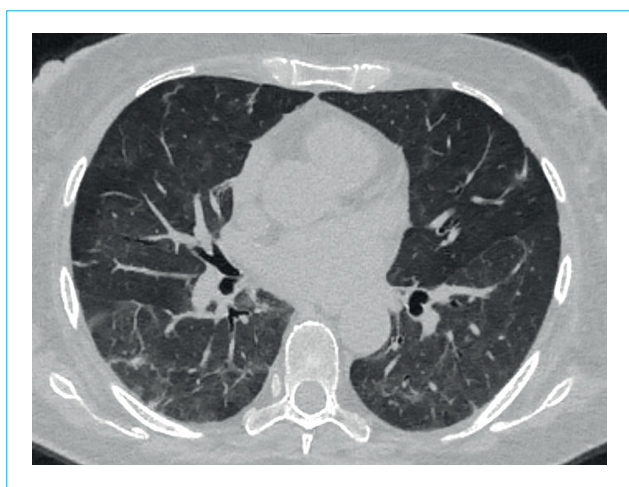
CT-scan of the chest. Reduction of previously identified lesions
